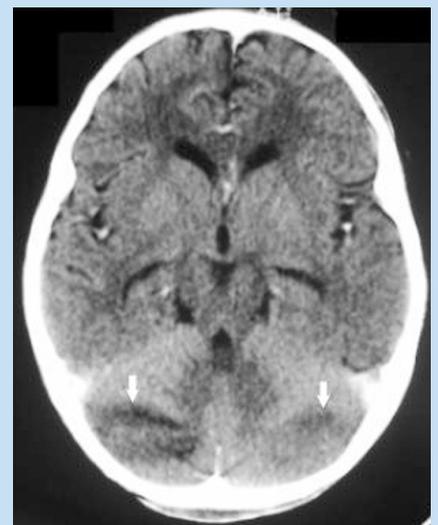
Axial post-contrast CT scan of the brain demonstrates bilateral asymmetrical hypodensities in the cortical and subcortical regions of the cerebellar hemispheres with no associated enhancement (arrows).
